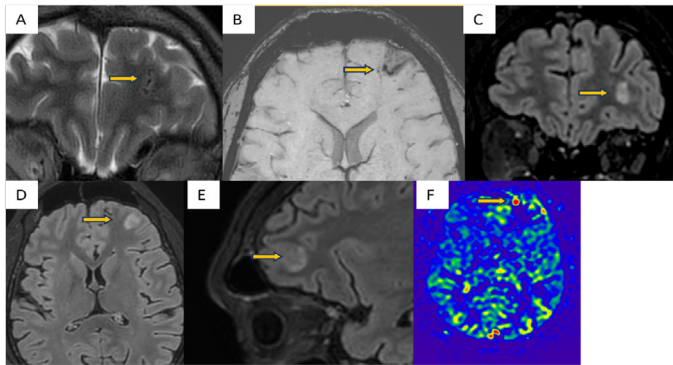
(A) - T2W coronal image showing hyperintense signal with a focus of hypointensity within in left frontal region (ARROW) (B) - SWI showing a prominent draining vessel in left frontal region (ARROW) (C), (D) and (E) - 3D FLAIR images in all planes showing prominent flow void with mild parenchymal edema in left frontal region (ARROW) (F) - ASL images showing hyper perfusion in the affected area (ARROW)
